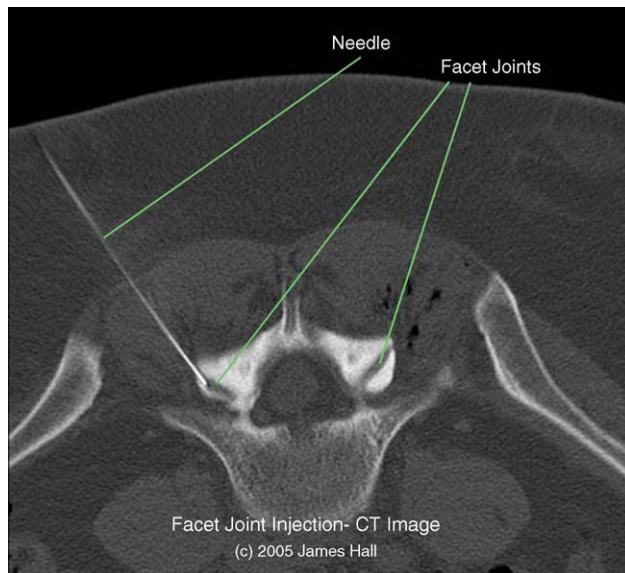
CT image of spinal needle placed within lumbar facet joint to inject mixture of local anesthetic and corticosteroid medications.
